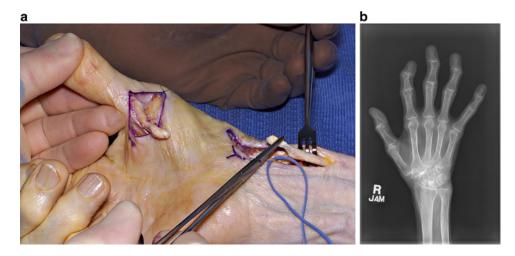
(a) A patient with attritional rupture of the flexor pollicis longus secondary to synovitis and arthritis. (b) AP radiograph demonstrating severe scaphotrapeziotrapezoid (STT) arthritis
